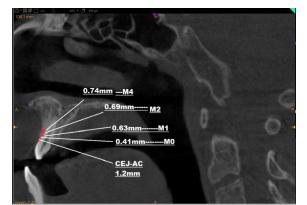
Measurements for the central incisor on CBCT(sagittal image).
